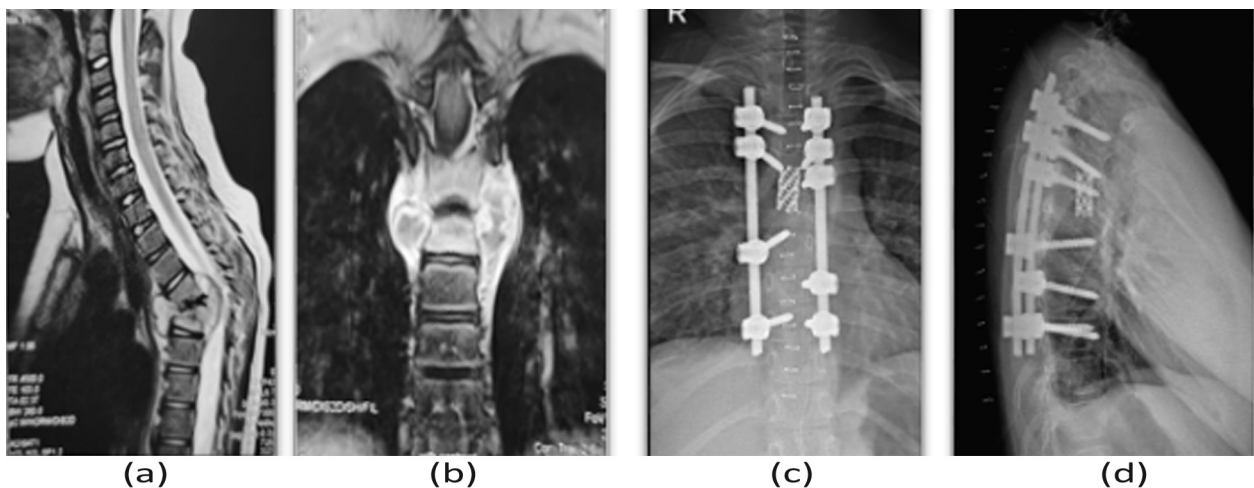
(a, b) shows T2-weighted MRI scan of a 9-year-old female with Tubercular Spondylodiscitis involving Dorsal 4th and 5th Vertebrae with kyphotic deformity and collection compressing on the spinal cord. Figure 2 (c, d) x-ray shows Posterior Approach debridement, anterior reconstruction with Harms Cage, and Posterior Instrumentation.
